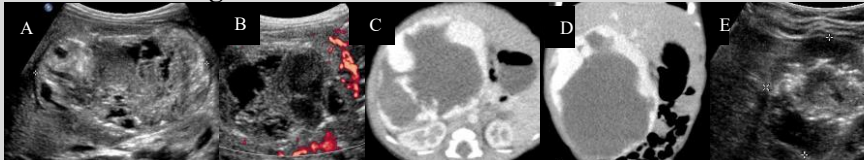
Fig A and B: Abdominal ultrasound in a 23-day-old baby shows large right hepatic lobe heterogeneous mass with septations. Color Doppler US demonstrates a hypovascular mass with vascular flow around its perimeter.
